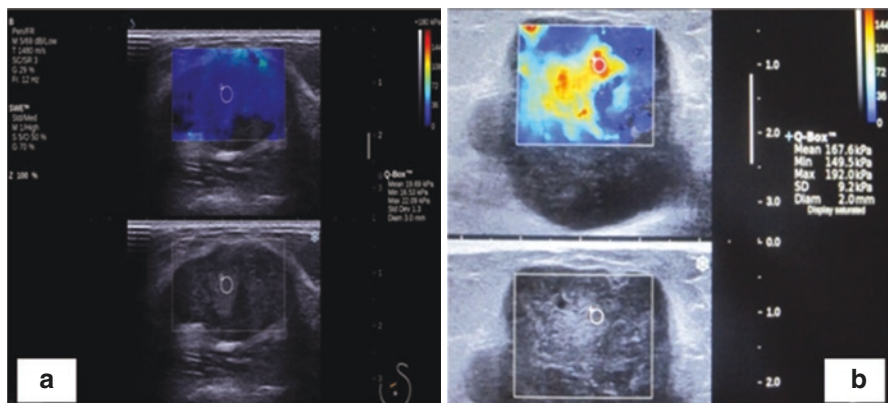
Ultrasound Elastography: (a) B-mode ultrasound showing round hypoechoic lesion with circumscribed lobulated margins. The lesion shows low elasticity values (homogeneous blue color with Emean 21.6 kPa) on shear wave elastography suggesting benignity; in contrast to (b) high elasticity values (heterogeneous color coding with red color on qualitative assessment and quantitative value of Emean 167.6 kPa) in another mass raising index of suspicion for malignancy
